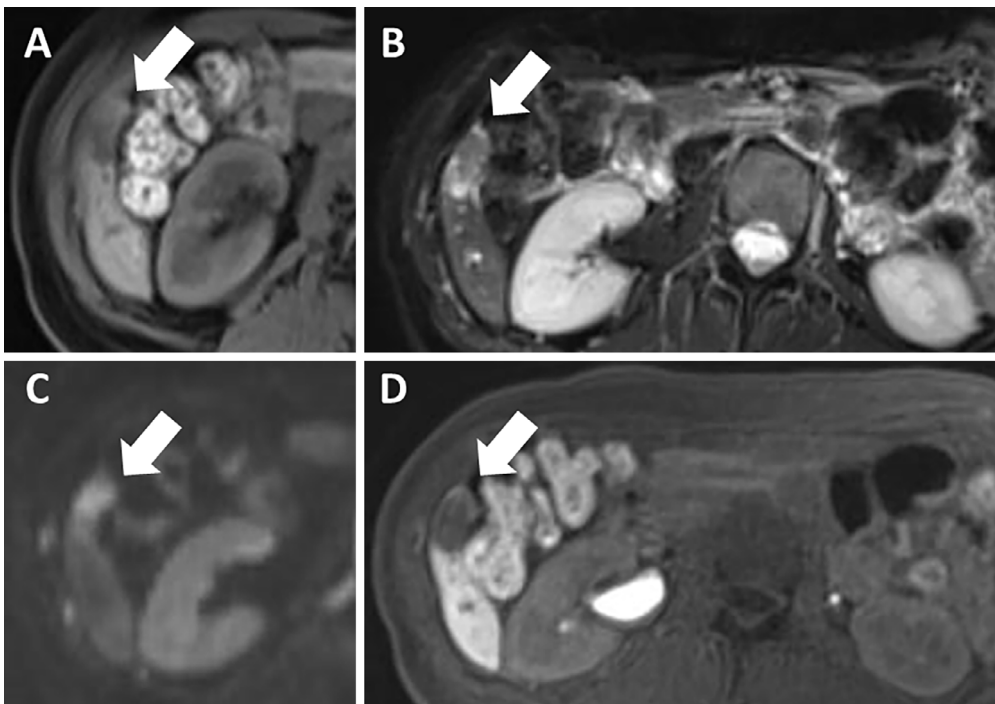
On ethoxybenzyl-magnetic resonance imaging performed two months before the patient's admission, the tumor (arrows) had not changed in size and was isointense compared with the normal liver on T1-weighted imaging (T1WI) (A). It was also highly heterogeneous on T2-weighted imaging (T2WI) (B) and diffusion-weighted imaging (DWI) (C); there was no uptake in the hepatobiliary phase (D).
